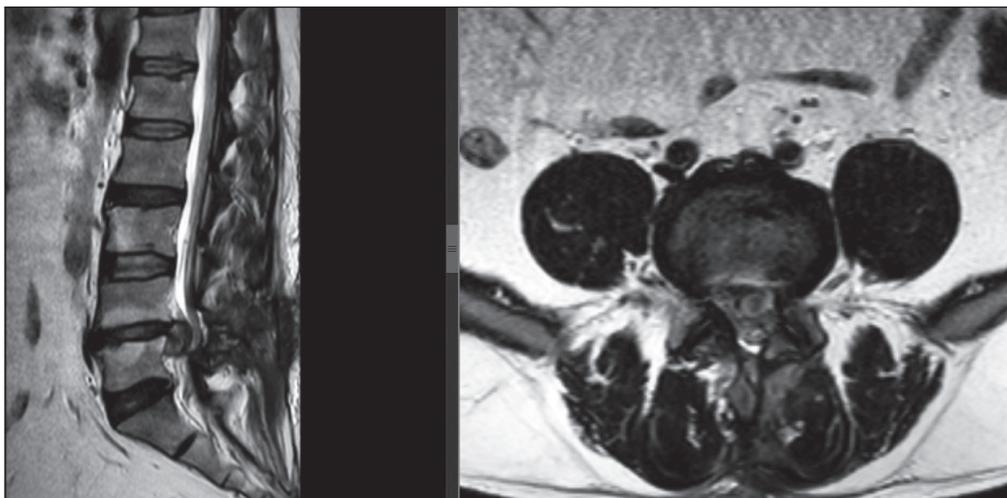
Preoperative lumbar MRI images of a patient who was operated on for a left recurrent lumbar disc herniation.
